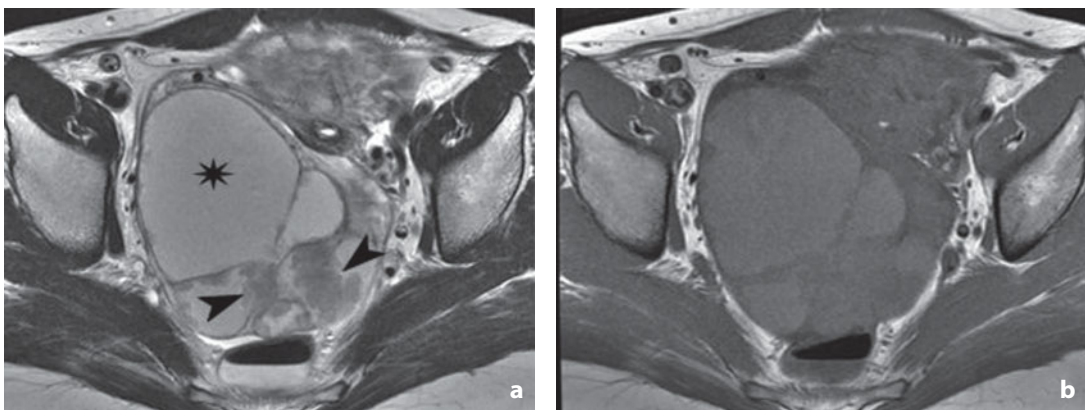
Magnetic resonance. Clear cell adenocarcinoma. a Axial T2-weighted MR sequence. Expansive 12 cm multilobular right adnexal mass with intermediate-high signal intensity fluid content (asterisk), irregular internal septations and hypointense intracystic solid nodulations (arrowheads). The residual ovarian parenchyma is compressed anteromedially with small follicles visible. The uterus is displaced to the left and anteriorly. b Axial T1-weighted image. The cystic component shows weakly hyperintense signal similar to elevated protein concentration while the septa and nodules are hypointense. (cont. →)
